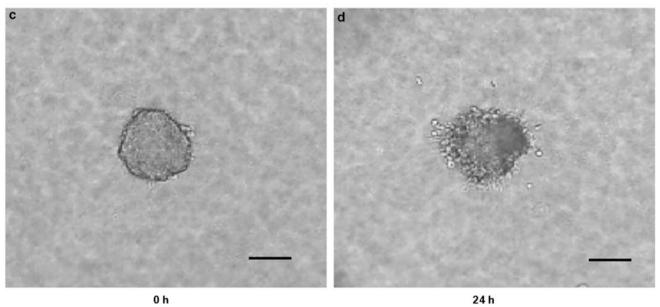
Hypoxia-induced CT invasion. (a, b) Invasion into a collagen matrix induced by incubation in a physiologically low-oxygen environment ($1\% O_2$) during the course of the experiment (24 h). (c, d) Incubation in atmospheric oxygen ($21\% O_2$) showed reduced invasion. Bars 150μ m.
